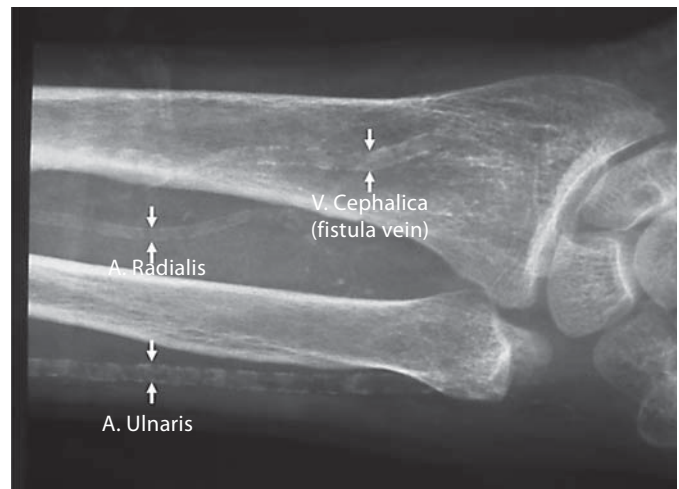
X-ray of the AV fistula arm with calcification of the AV fistula and both neighbouring arteries.
